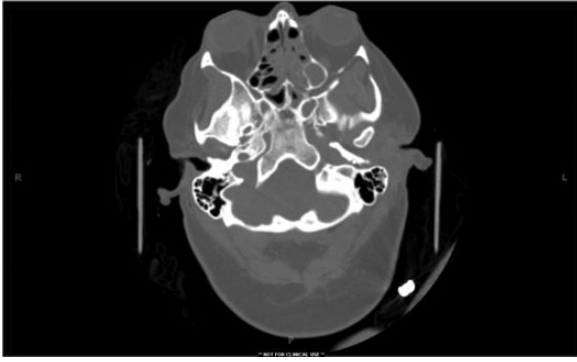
Computed tomography head demonstrating bilateral ethmoid sinusitis and left maxillary sinusitis.
